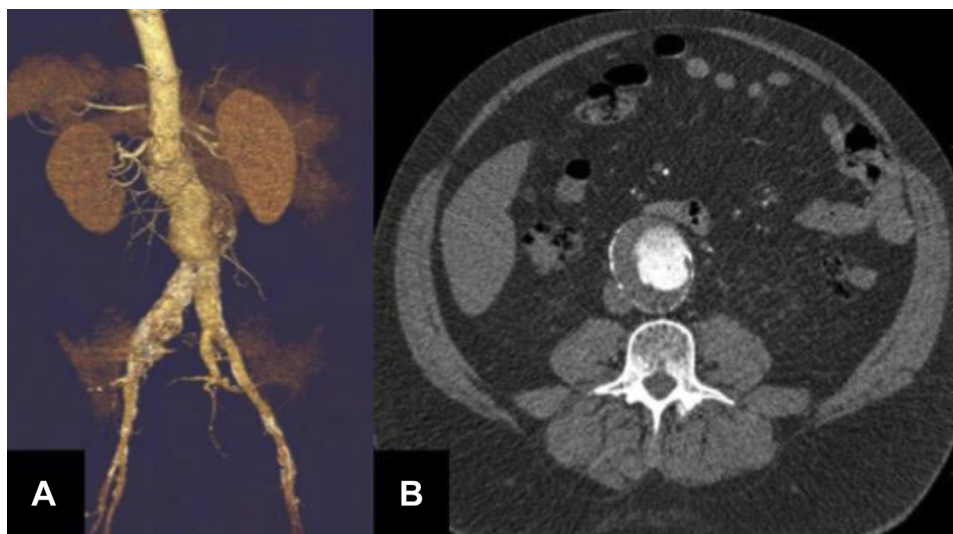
A, Posteroanterior three-dimensional reconstruction of complex juxtarenal abdominal aortic aneurysm. B, Axial computed tomography (CT) image of same juxtarenal abdominal aortic aneurysm with intramural thrombus within the sac.
